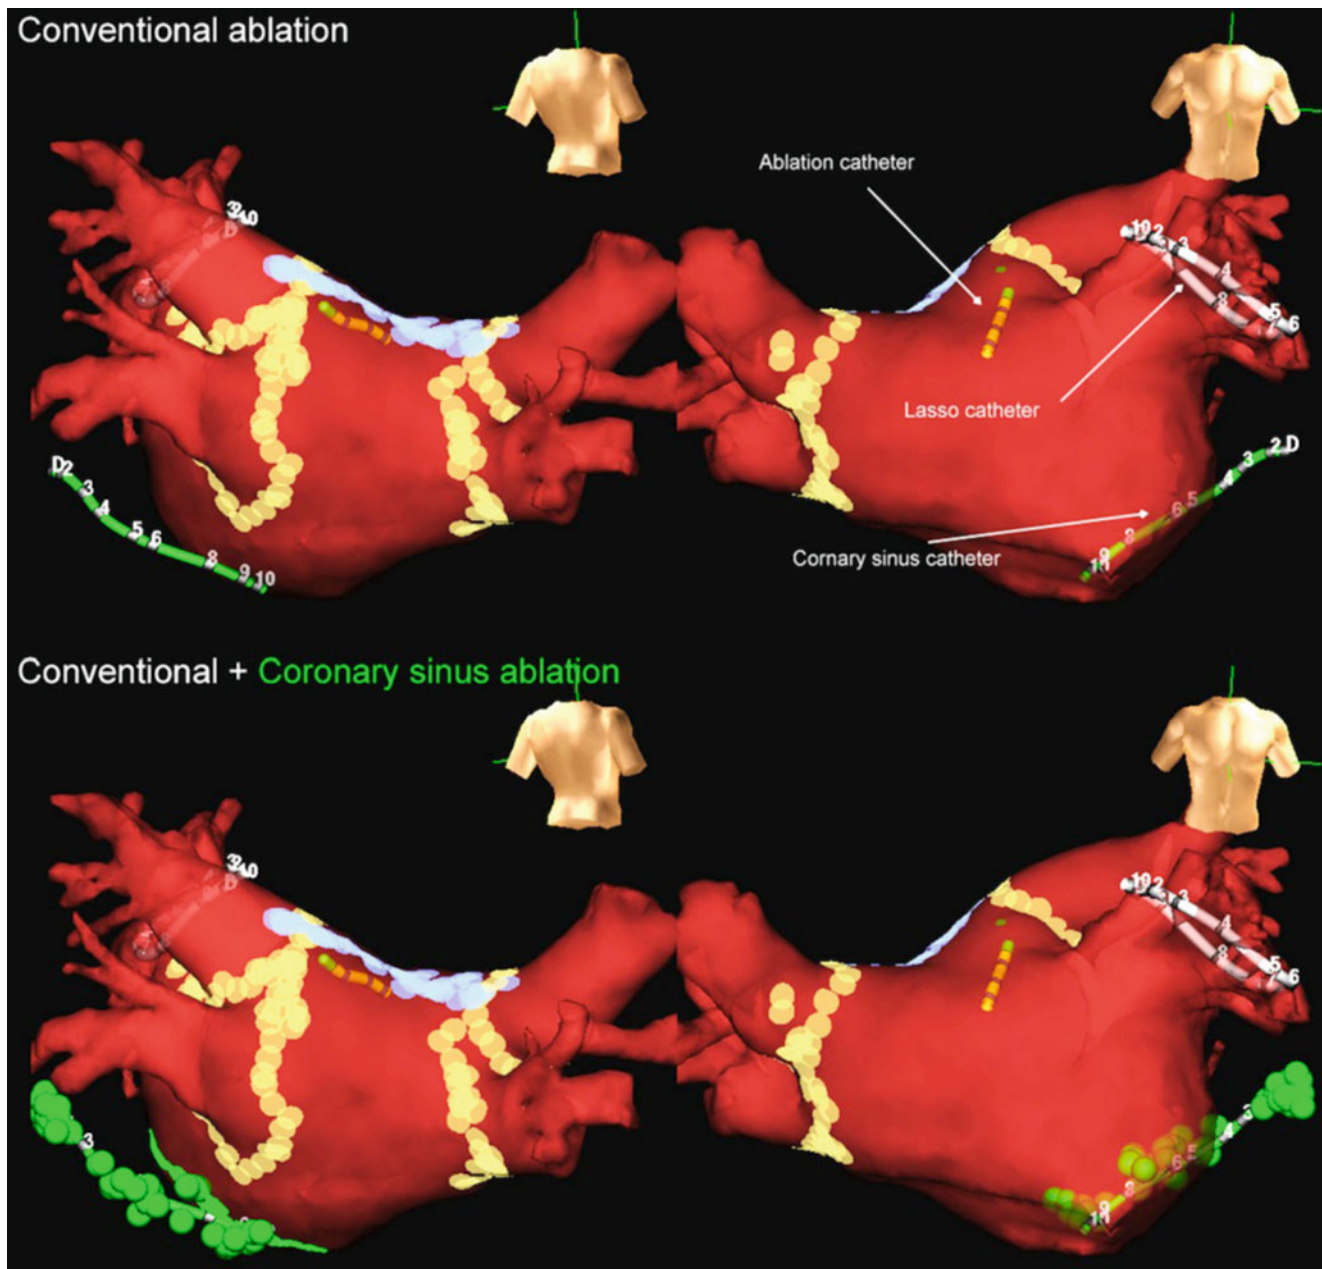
The linear ablation points – pulmonary vein isolation (yellow in color), roofline (blue) and coronary sinus (green) – are marked on the chamber geometry created by EnSite NavX system and fused with the CT image (NavX fusion) in a patient with permanent atrial
